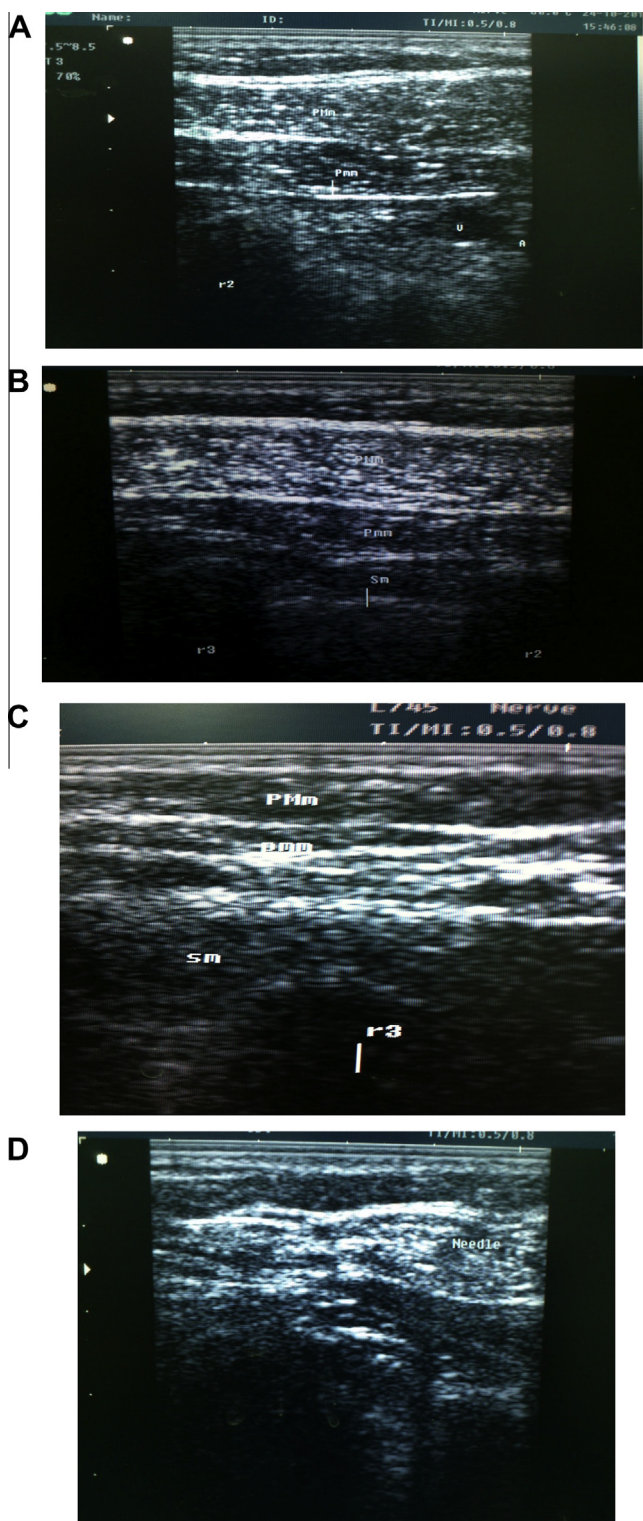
Ultrasound scanning of Pecs blocks I and II, figures A and B respectively. Local anesthetic was injected in the plane between PMm and Pmm, Pecs block I (figure C) and inbetween Pmm and sm, Pecs block II (figure D). The needle is seen in the fascial plane between Pmm and sm, figure D. PMm = Pectoralis major muscle, Pmm = Pectoralis minor muscle, sm = serratus muscle, A = axillary artery, V = axillary vein, r2 = rib2, r3 = rib3.
